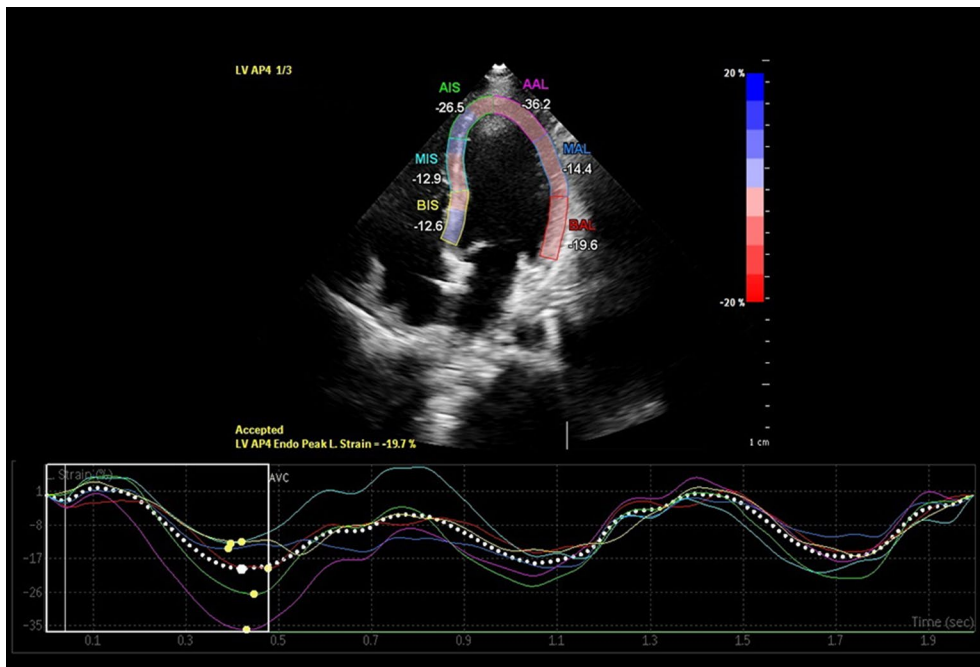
Two-dimensional speckle-tracking echocardiography for left ventricular 4-chamber longitudinal strain.
